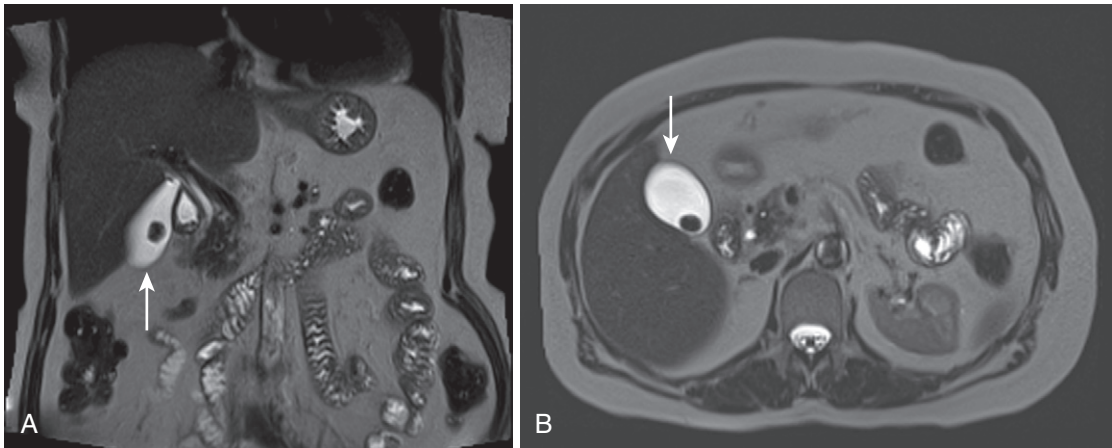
SSFSE image resistance to motion and susceptibility artifact and utility for fluid-filled structures. Coronal (A) and axial (B) heavily T2-weighted SSFSE images depict fluid-filled structures, such as the stone-containing gallbladder (*arrow*) and loops of bowel, with great detail and clarity and absence of susceptibility and motion artifact.
